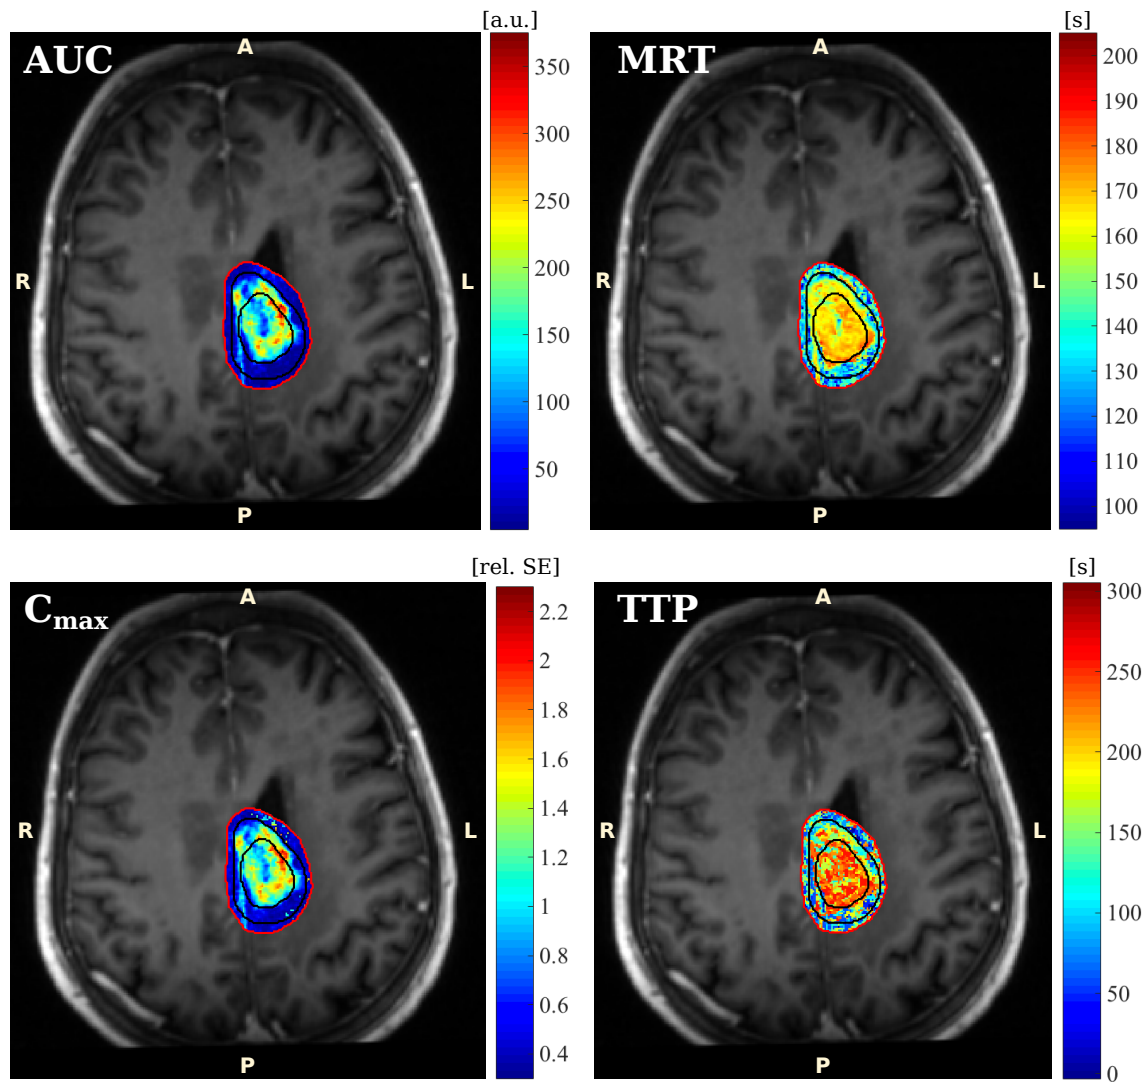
Parameter maps of semi-quantitative parameters AUC , MRT , C_{max} and TTP from non-compartmental analysis of DCE MRI data, acquired on the first day of radiotherapy, in patient n° 3. Parameters were calculated within the PTV red outer contour). Here, they are shown as overly of the static, T_1 weighted contrast enhanced MRI for localization. GTV and CTV contours are indicated in black.
